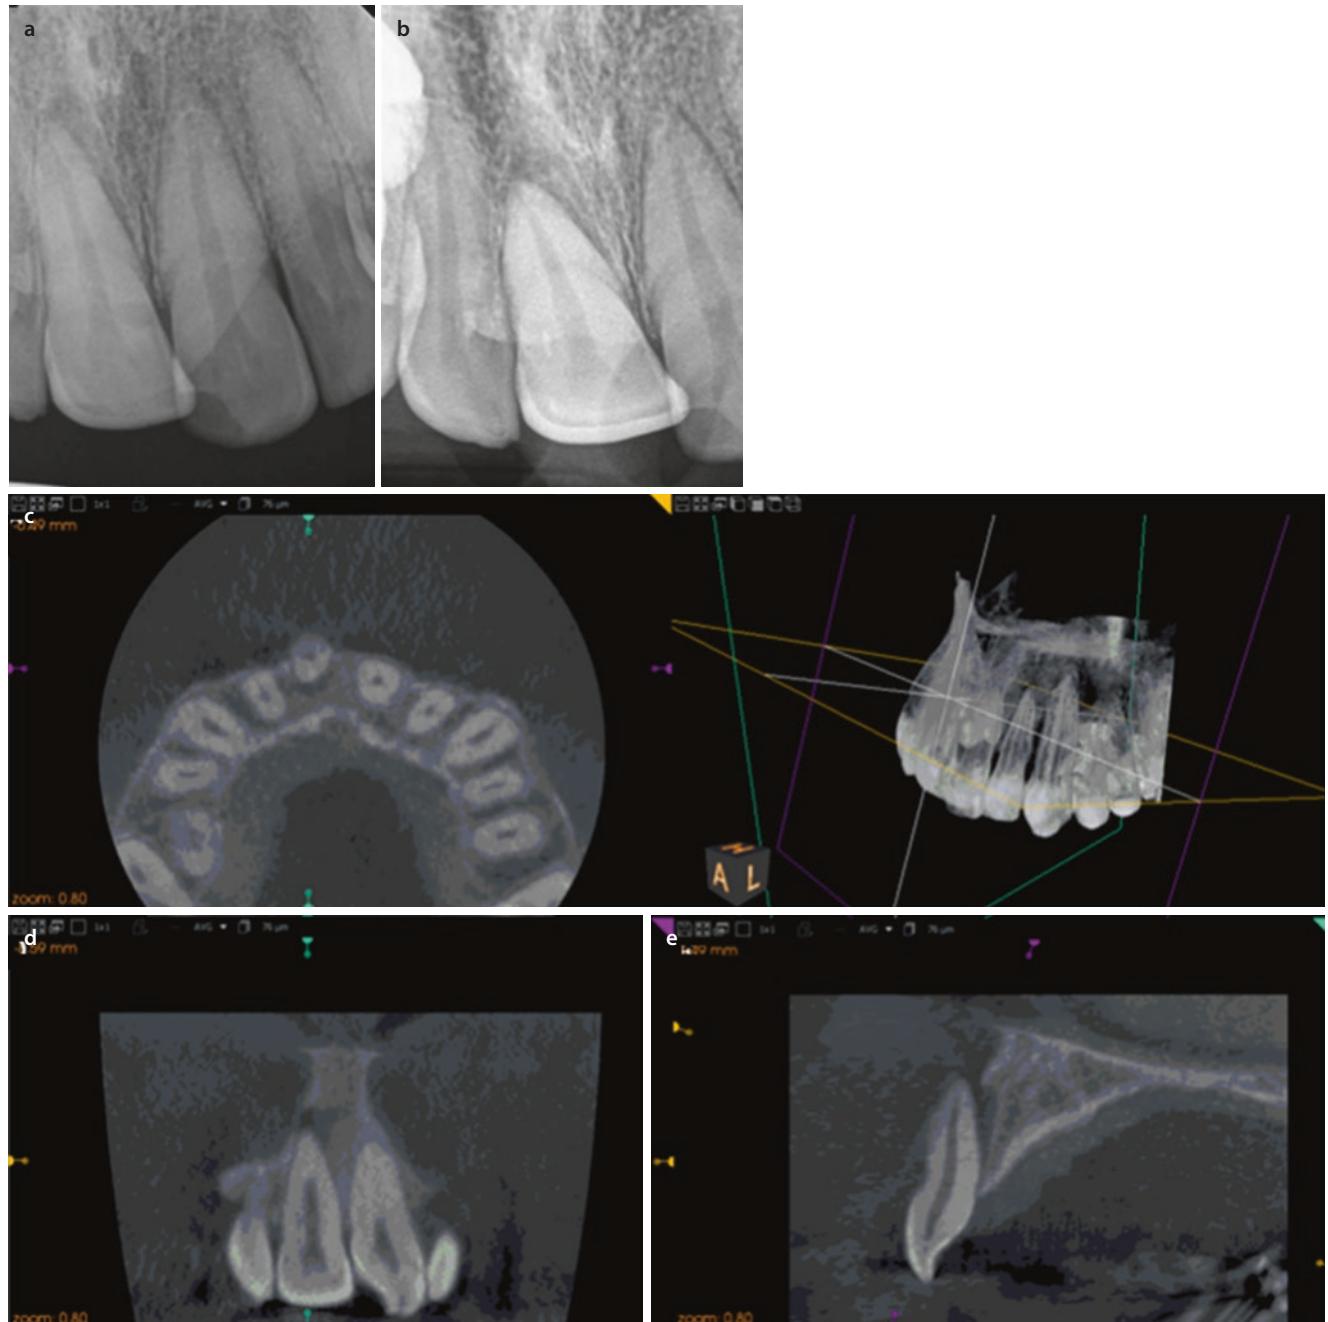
a, b Pre-operative images of lateral luxation on tooth #8 and uncomplicated crown fracture on tooth #9. Soft-ware imaging from Kodak depicting the CBCT axial c, sagittal d, and coronal e orthogonal
